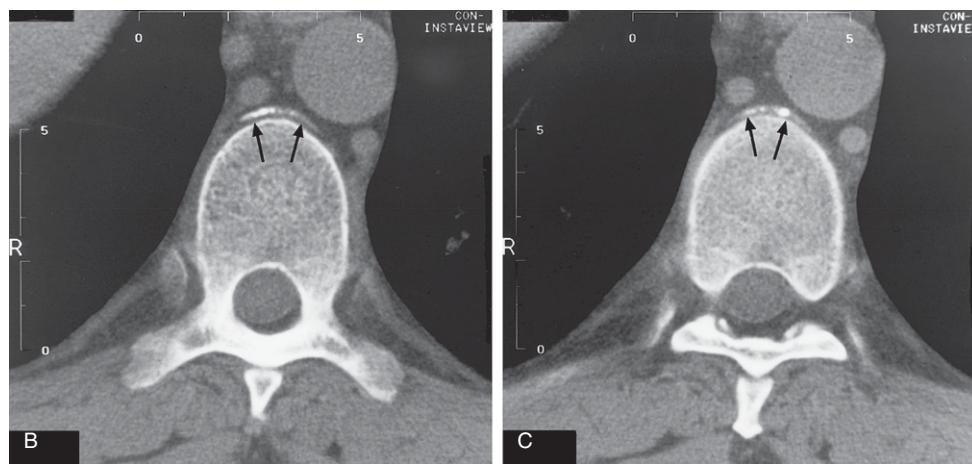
Cont'd (B and C) Thoracic spine CT axial images through the 8th thoracic vertebra showing the calcification in the anterior longitudinal ligament (arrows).
